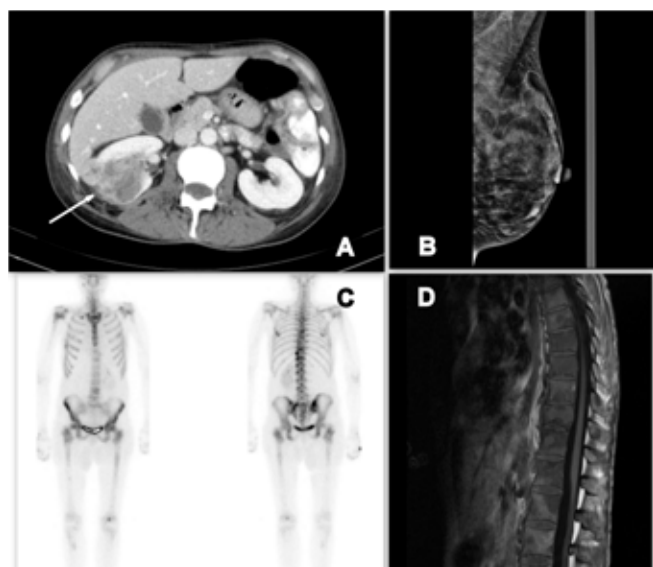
Radiological findings, (A) Computed tomography scan showing a solid mass measuring 7x4 cm in right kidney (arrow). (B) Mammography detected a solid mass in lower inner quadrant of the left breast. (C) Bone scintigraphy showed multiple bone metastasis on hips, ischium, sacroiliac joints, thoracic spine and right costal arches. (D) Sagittal T-1 weighted image of thoracic spine revealed multiple hypointense osteolytic lesions within the vertebrae.
